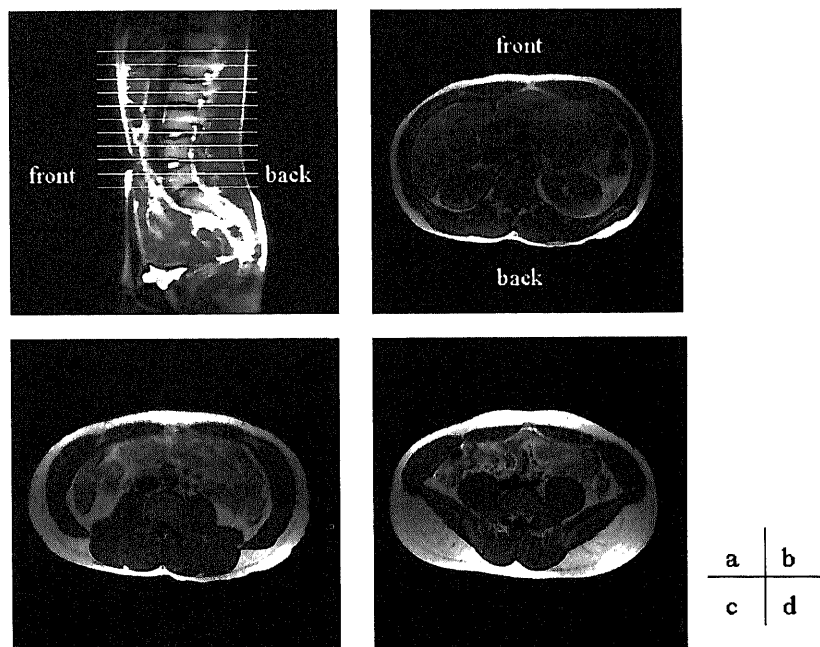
Measurement sites in the lumbar region by MRI
